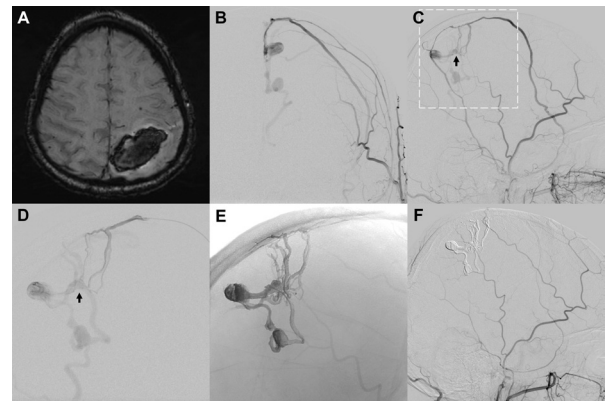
Treatment of a ruptured dural arteriovenous fistula (DAVF) near the superior sagittal sinus with Squid 18. Example of a patient who developed an intracranial hemorrhage in the left parietal lobe (A; susceptibility-weighted MRI) due to rupture of a Cognard type IV DAVF near the superior sagittal sinus. In an angiogram of the left external carotid artery (B, C) feeders of the DAVF from the middle meningeal artery can be identified. The frontal feeder was catheterized with a marathon microcatheter. A superselective angiogram of the fistula is shown in (D). After positioning of the microcatheter near the fistula point (black arrow in C and D), complete embolization using Squid 18 was achieved (embolic agent cast visualized in E). (F) The angiogram 3 months after the treatment shows complete occlusion of the DAVF.
